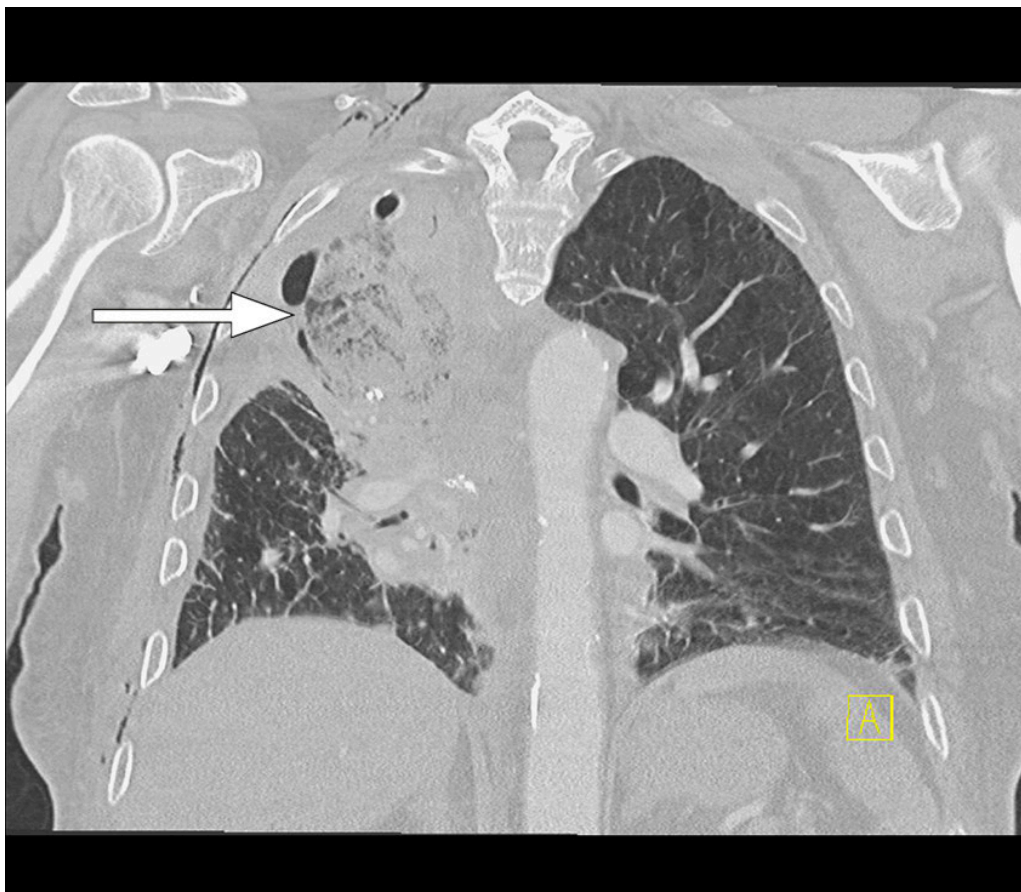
Contrast-enhanced chest CT obtained on postoperative day 1 following primary surgery. Coronal section with lung window demonstrates ground-glass opacities, consolidations and interlobular septal thickening in the middle lobe. There was a small pneumothorax and small amounts of pleural effusion on the right side, to be expected postoperatively. The image shows the chest drain in place with its tip over the apex of the right lung.
